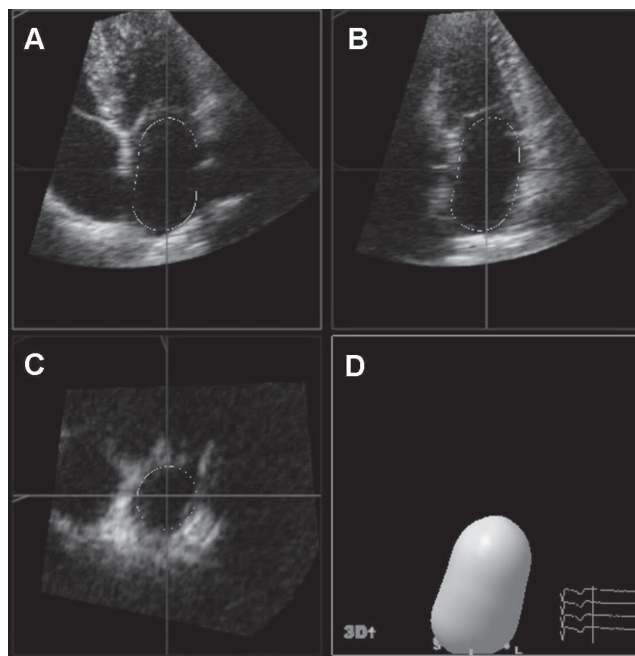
Real-time three-dimensional echocardiogram for the assessment of LA volumes. Panels A to C represent the coronal, sagittal and transverse planes, respectively. With the use of a 5-point tracing algorithm, LA volumes can be obtained throughout the cardiac cycle, represented by the 'shell' in panel D. In this example, LA maximum volume was 53 ml.
